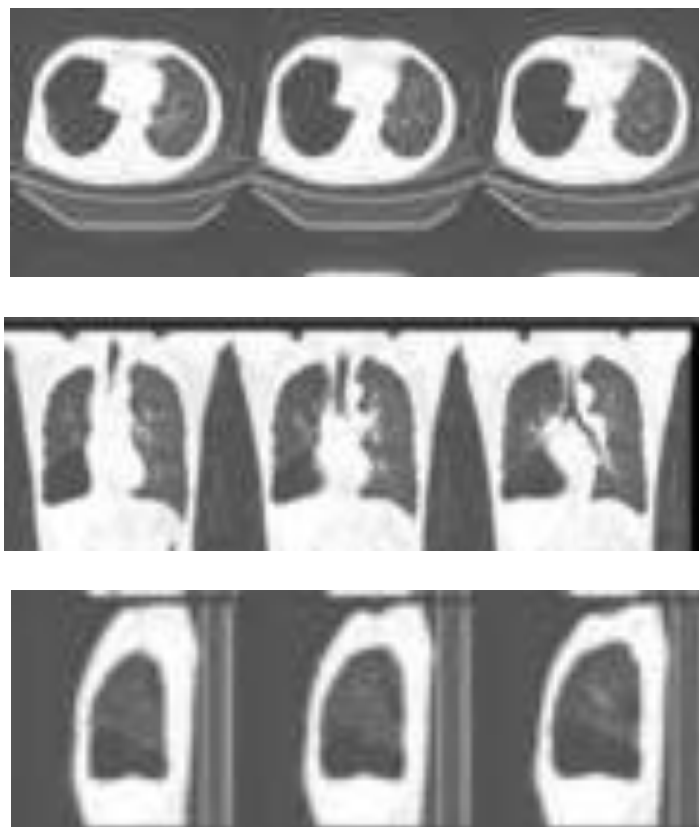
Preoperative thoracic chest CT-scan.
